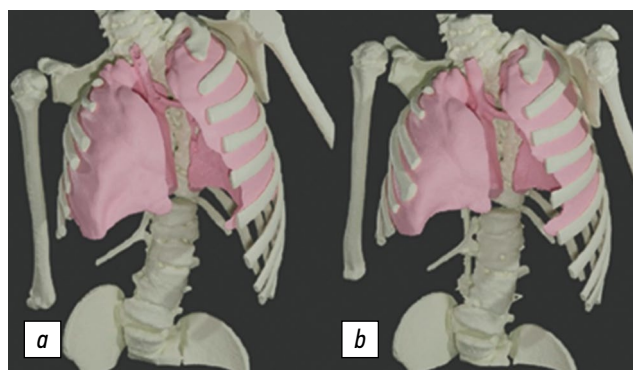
CT volumetry. Patient, 6 years old: *a*, the lungs before the surgery; *b*, appearance 6 months after the surgery: a change in the spatial position of the shoulder girdle, an increase in the hemithoracic volume on the concave side, and an increase in the right lung by 72.8 cm³ (22.6%) and the left lung by 62.3 cm³ (20.7%). The total lung volume 6 months after the surgery increased by 21.7% (135.1 cm³)
